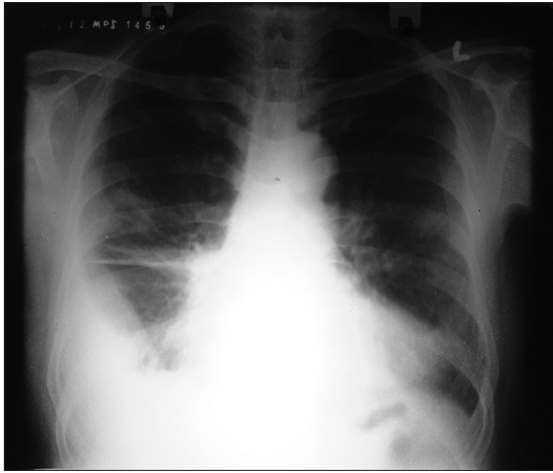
Chest X-ray taken after 2 months of treatment showing clearing of the lung fields
